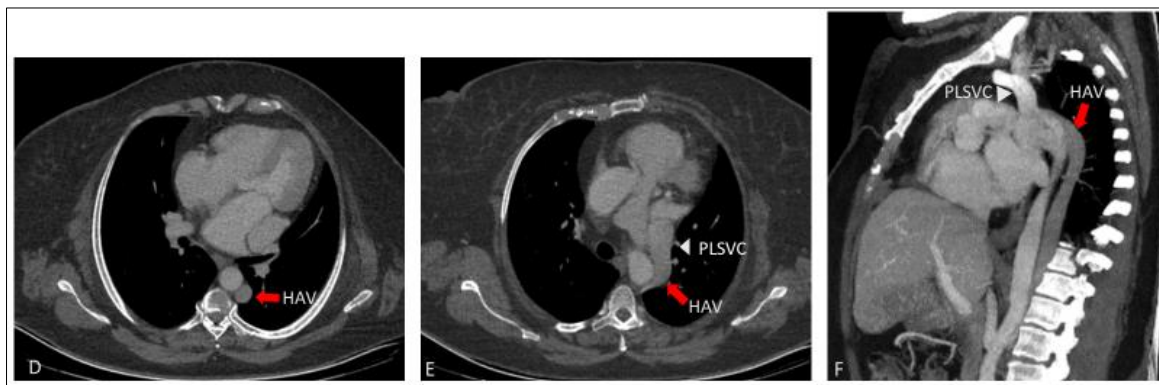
Axial CT images (D, E) and oblique sagittal maximum-intensity-projection image (F) showing a dilated hemiazygos vein (red arrow) draining into the persistent left superior vena cava. HAV = hemiazygos vein; PLSVC = persistent left superior vena cava
